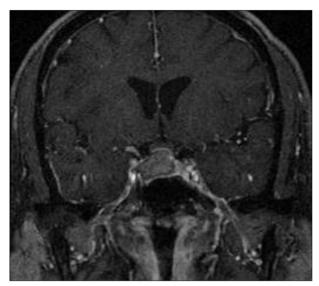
Gadolinium-enhanced T1 weighted coronal magnetic resonance image of the brain showing a 1.9×1.3 cm-sized mass indicative of subacute hemorrhage in the pituitary fossa with extension toward the right cavernous sinus, upward displacement of the optic chiasm and erosion of the sellar floor.
